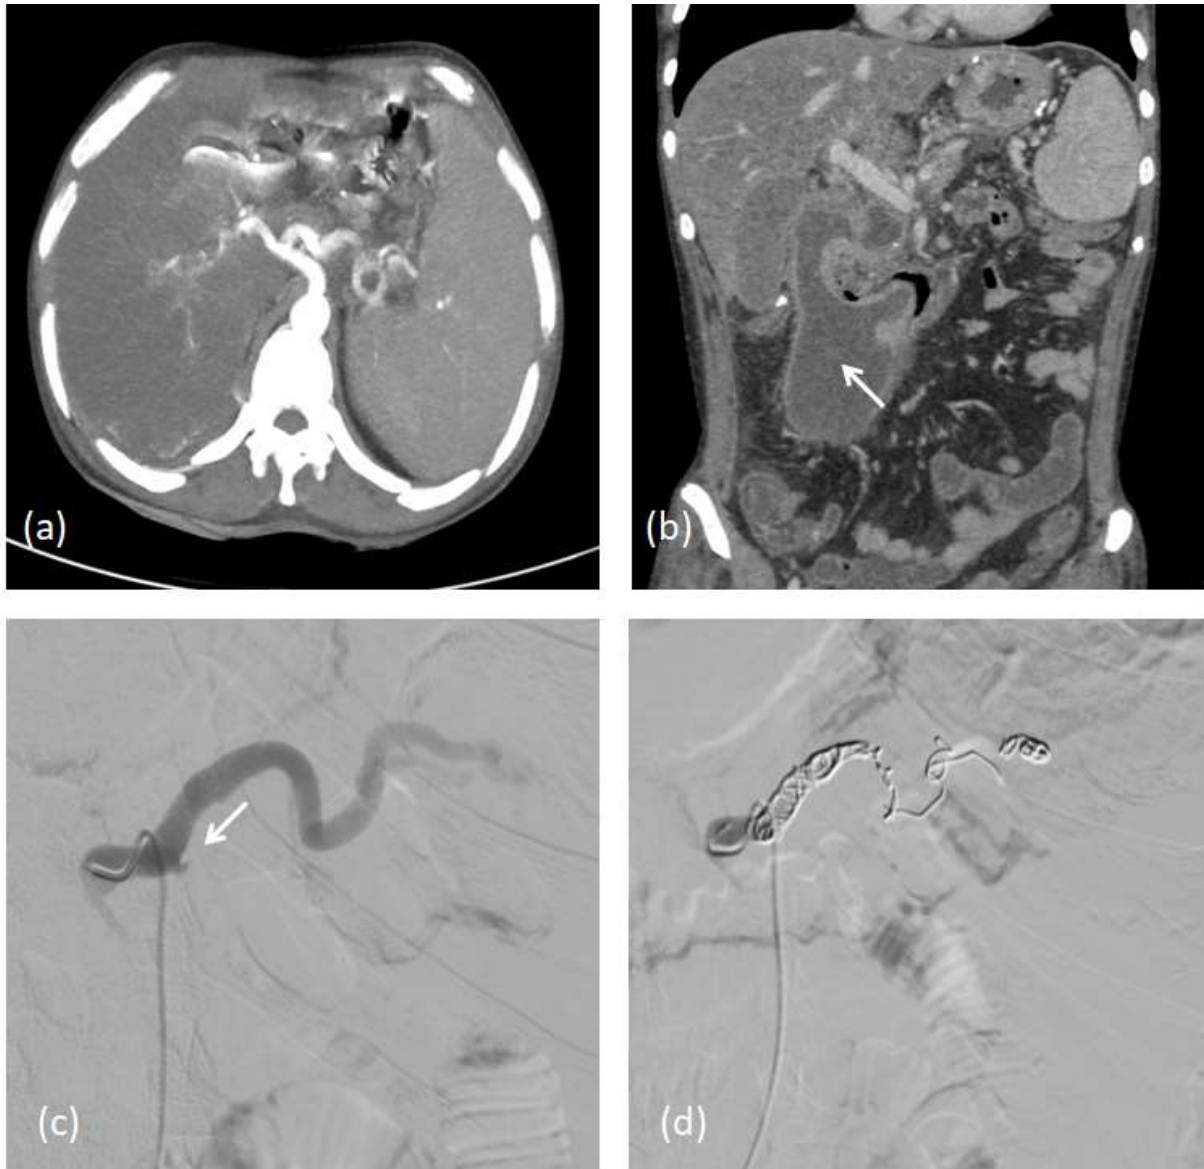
Axial post contrast CT scan image shows peri-splenic hematoma with non-enhancing focal area in spleen likely infarct.
